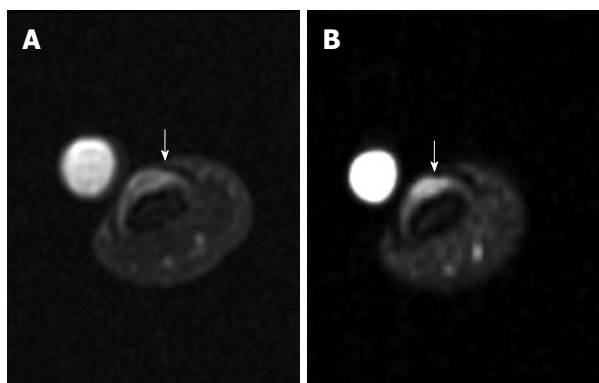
Subungual glomus tumor. A: Axial proton-density-weighted MR image of the left thumb shows a small subungual tumor (arrow); B: Fat-saturated gadolinium-enhanced T1-weighted image shows obvious enhancement of the tumor (arrow). MR: Magnetic resonance.
